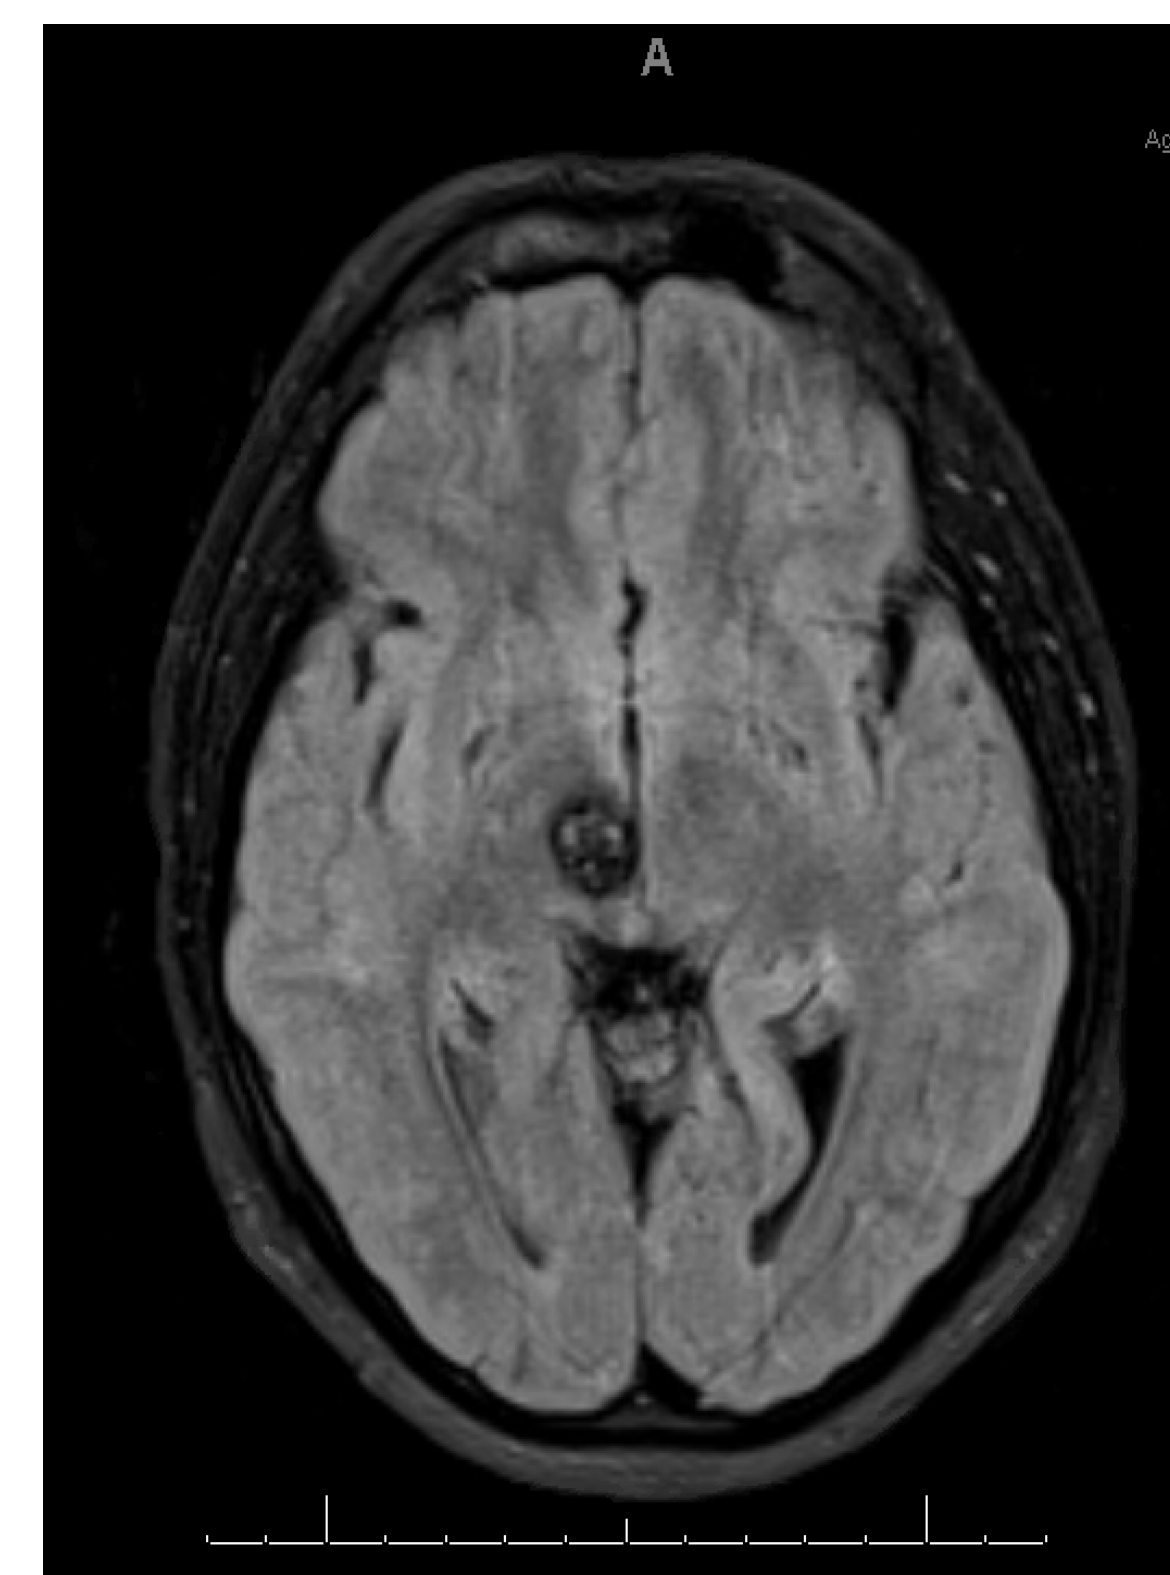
Axial view of MRI revealing cavernous angioma of R cerebral peduncle.
